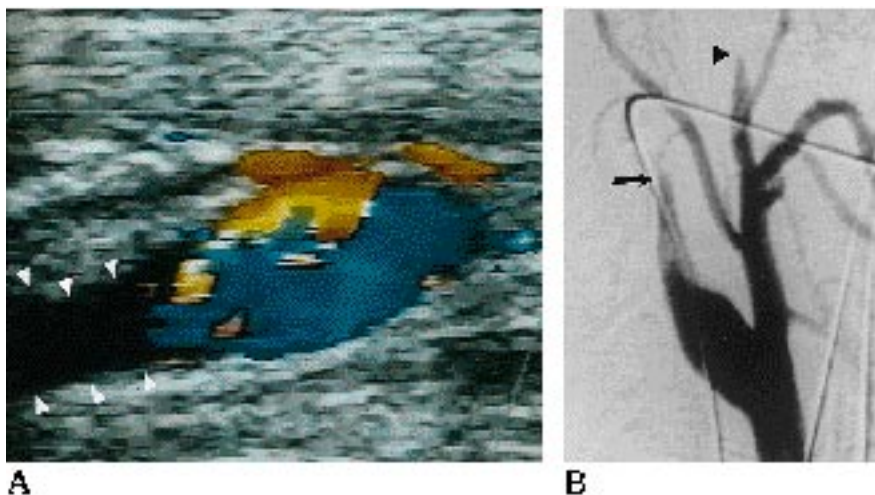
A, Longitudinal color Doppler sonogram of the carotid bulb. Marked reversal of flow within the bulb and lack of color of the proximal internal carotid artery (ICA) are consistent with occlusion (*arrowheads*).
